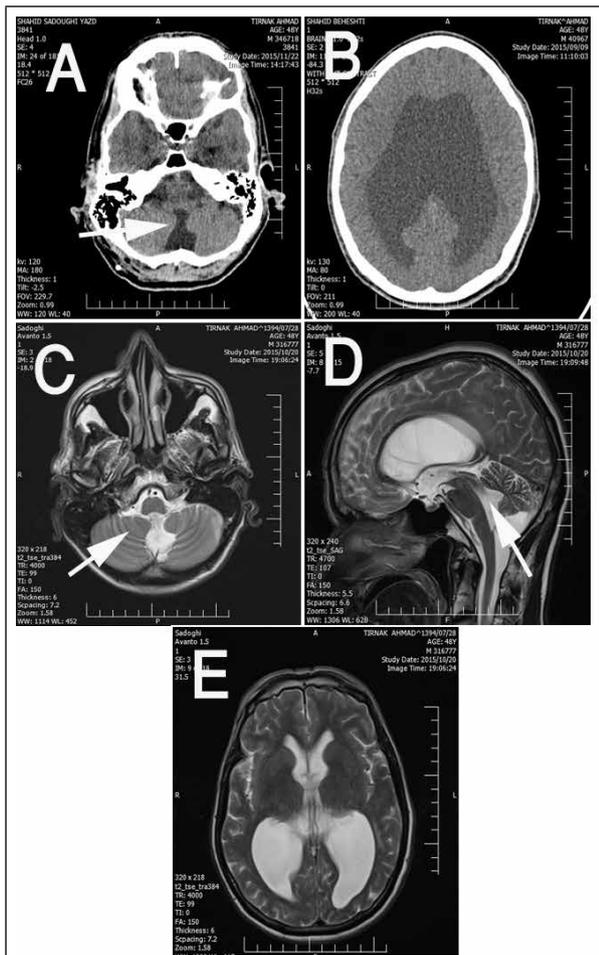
Non-enhanced CT scan demonstrates partial agenesi of the vermis, and communication between the fourth ventricle and the cisterna magna (blue thick arrow) in normal sized posterior fossa (A). Non-enhanced CT scan showing dilatation of lateral ventricles with abnormal orientation (B). Axial T2-weighted image depicting agenesi of the inferior vermis, (yellow arrow) resulting in communication between the fourth ventricle and the cisterna magna (C). Sagittal T2-weighted image showing partial agenesi of posterior body of corpus callosum, also linear signal void in aqueduct of sylvius (red arrow) due to stenosis and non-communicating hydrocephalus (D). Axial T2-weighted image depicting colpocephaly (E).
